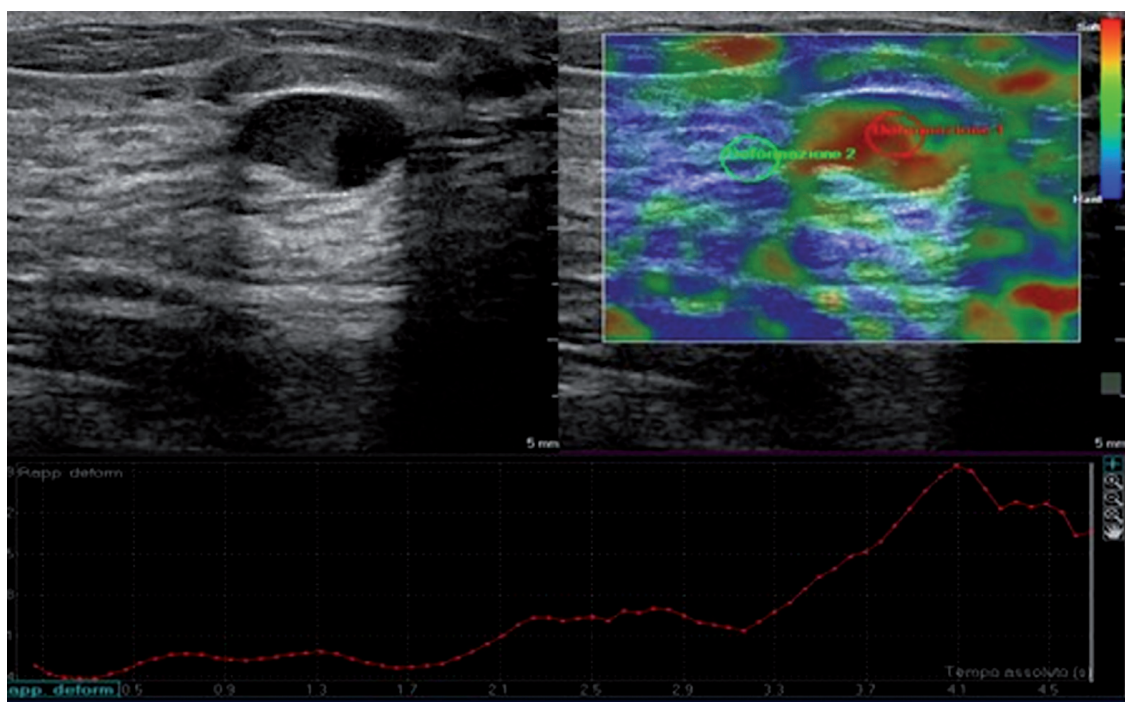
Score 1: The presence of colorimetric tristratified appearance (blue-green-red) at elastosonographic evaluation typical of cystic formations.
